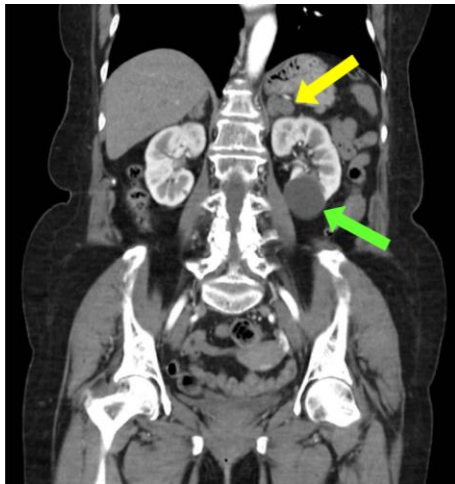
Bilateral adrenal enlargement (yellow arrow) and simple kidney cyst (green arrow), on CT
